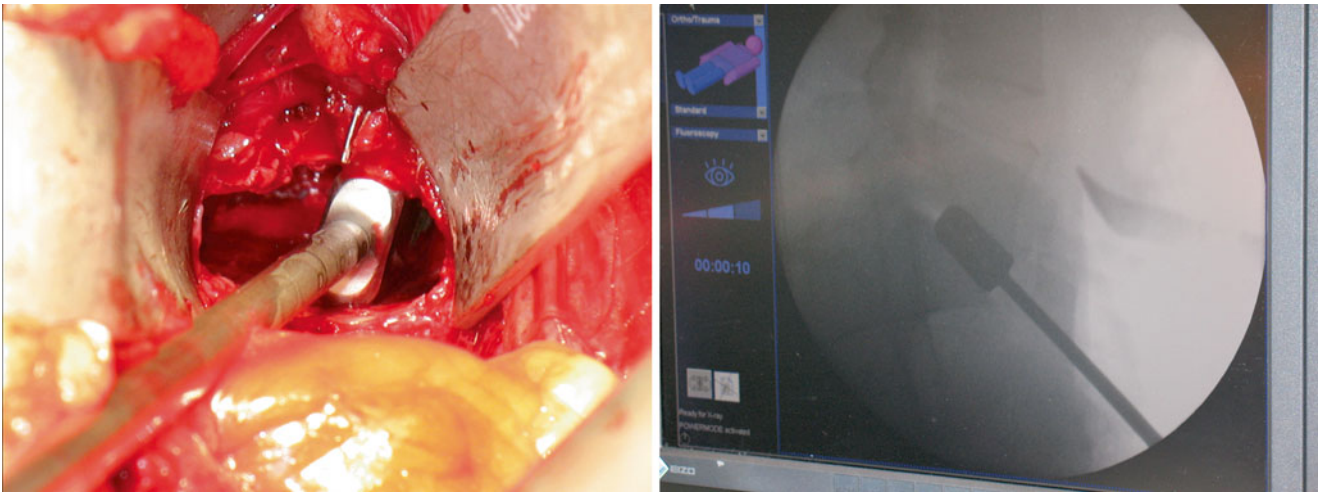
Intraoperative photo (*left*) of paddle distractor in the disc space after complete discectomy is completed. Radiographic lateral intraoperative image (*right*) demonstrating paddle distractor in position
